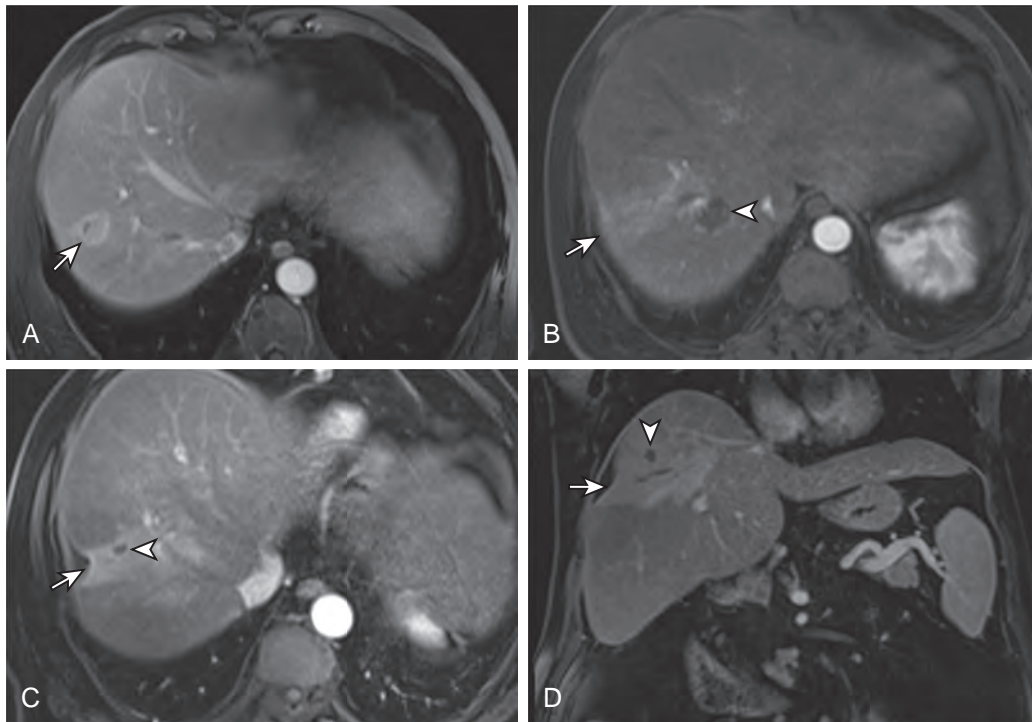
Effect of radioembolization on the adjacent hepatic parenchyma. A. MR image shows a small enhancing hepatoma (arrow). B. Close follow-up post-therapy image shows ill-defined enhancement of adjacent parenchyma in a vascular distribution (arrow), suggesting perivascular edema and inflammation. An incidental hemangioma is seen (arrowhead). C and D. Follow-up MR images reveal the lesion as a much smaller nonenhancing focus, suggesting excellent treatment response (arrowheads). The adjacent parenchyma enhances in a delayed fashion with capsular retraction (arrows), suggesting hepatic fibrosis from radiation effect.
